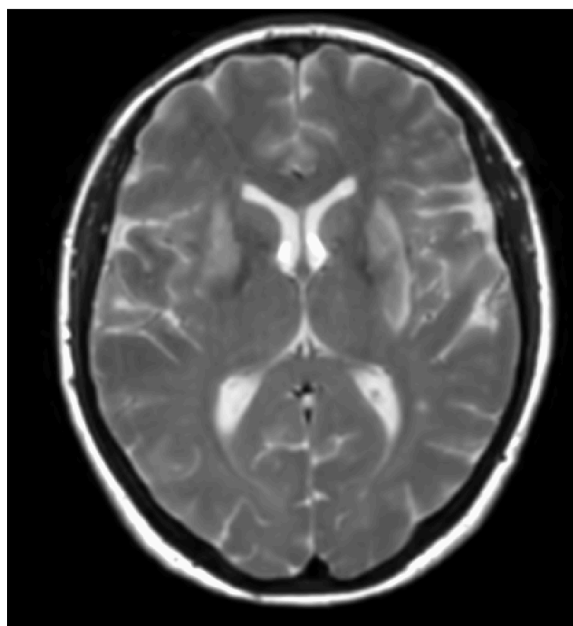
An example of axial T2-weighted MRI image of the brain.
